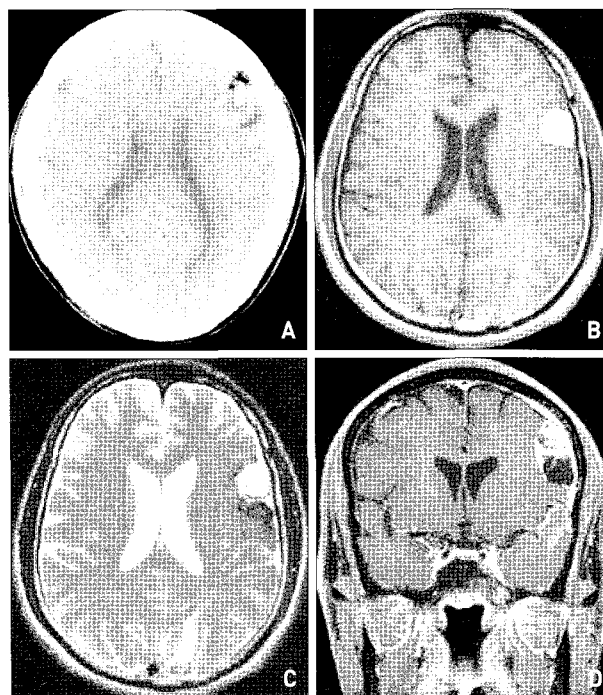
Brain computed tomography scan revealing a 3×2 cm sized mass (A). Magnetic resonance image shows a fat containing extraaxial mass with enhancing component at the left frontal convexity and another small well-enhancing nodular lesion at the left posterior parietal (precuneus) (B, C, D).
